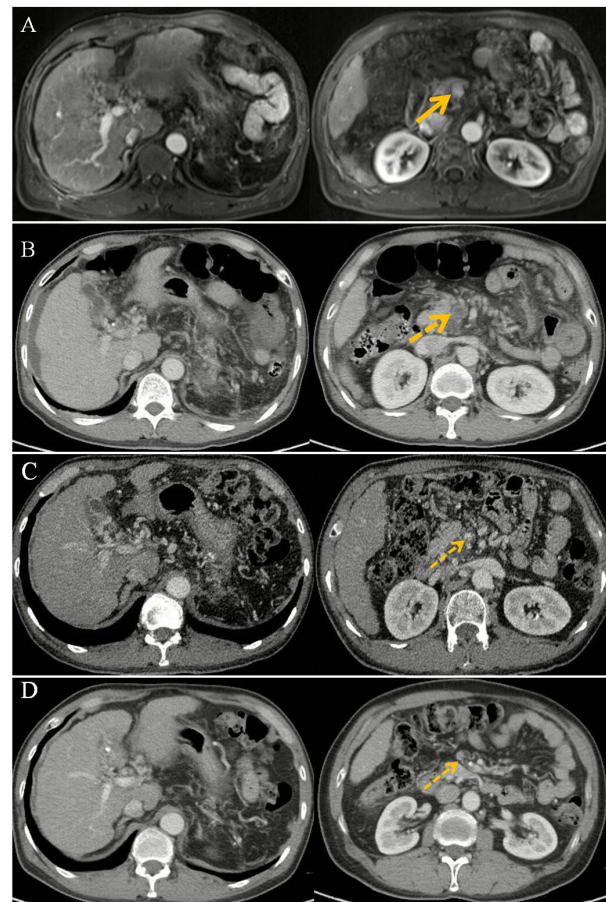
Axial views. (A) contrast-enhanced magnetic resonance imaging performed on May 29, 2017 showing patent mesenteric vein (solid arrow); (B) computed tomography angiography performed on June 13, 2017 showing complete thrombosis in the mesenteric vein (dotted arrow); (C) computed tomography angiography performed on July 19, 2017 showing partial recanalization of mesenteric vein thrombosis (thin dotted arrow); (D) computed tomography angiography performed on June 5, 2018 showing partial recanalization of mesenteric vein (thin dotted arrow) with collateral circulation around the mesenteric vein.
